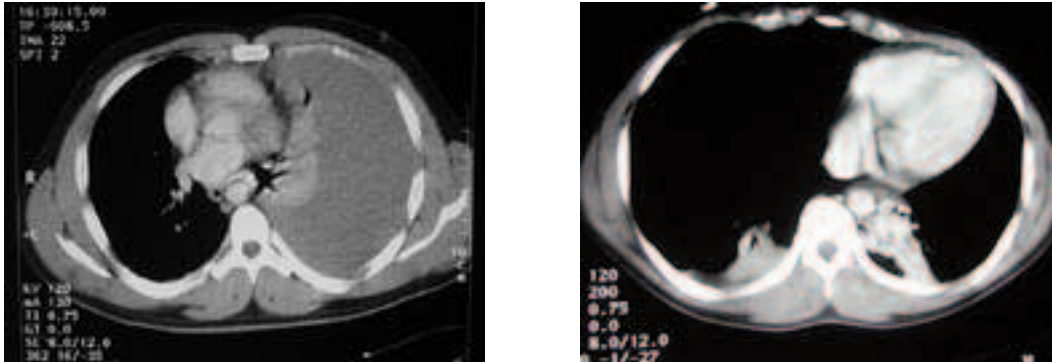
The CT image on the left is a hemothorax. Note the light color of the right hemithorax where the blood is collected and the lack of mediastinal shift. The CT image on the right is a tension pneumothorax. Note the blackness of the left hemithorax where air is trapped under pressure and the shift of the mediastinum to the right side.
